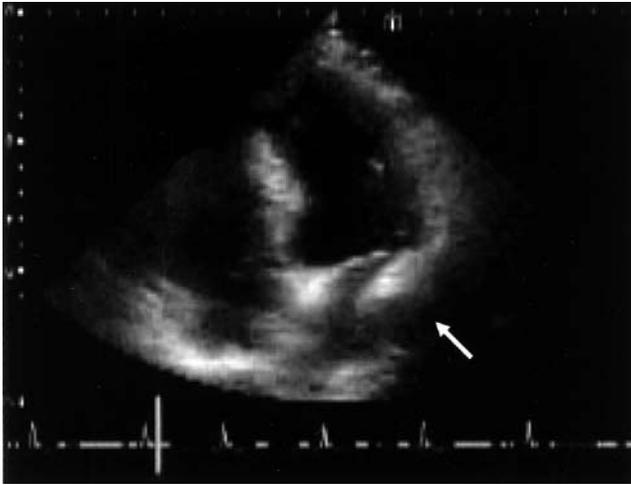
Echocardiographic finding. Compression of the left atrium from outside because the lung cancer is visible, suggesting tumor invasion to a point near the posterior cusp of the mitral valve.
